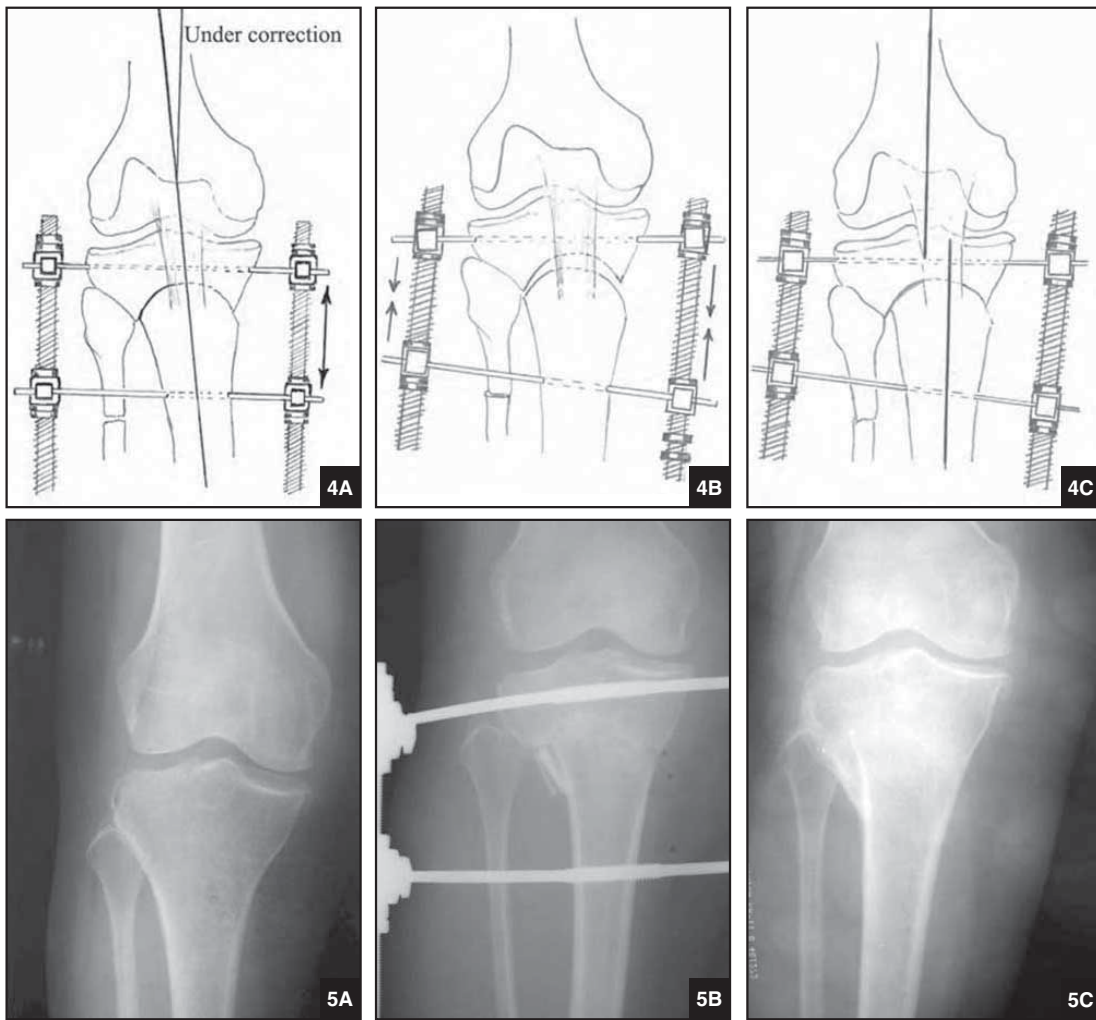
Undercorrection (assessed postoperatively) is corrected by first distracting the appropriate side until the desired degree of correction/HKA angle is achieved (A). Compression is performed on either side simultaneously to reimpact the osteotomy (B). Final alignment achieved (C). Figure 5. Radiographs taken preoperatively (A), immediately following the operation (B), and at final follow-up (C).
